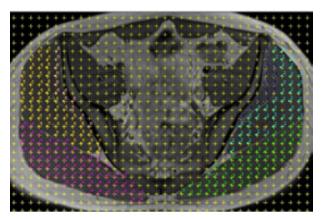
The gridding process on MR images executed in ImageJ software and the determination of points corresponding to right-left gluteal muscles (m. gluteus minimus, m. gluteus medius, m. gluteus maximus). The image was taken from between the second and third sacral notch.
